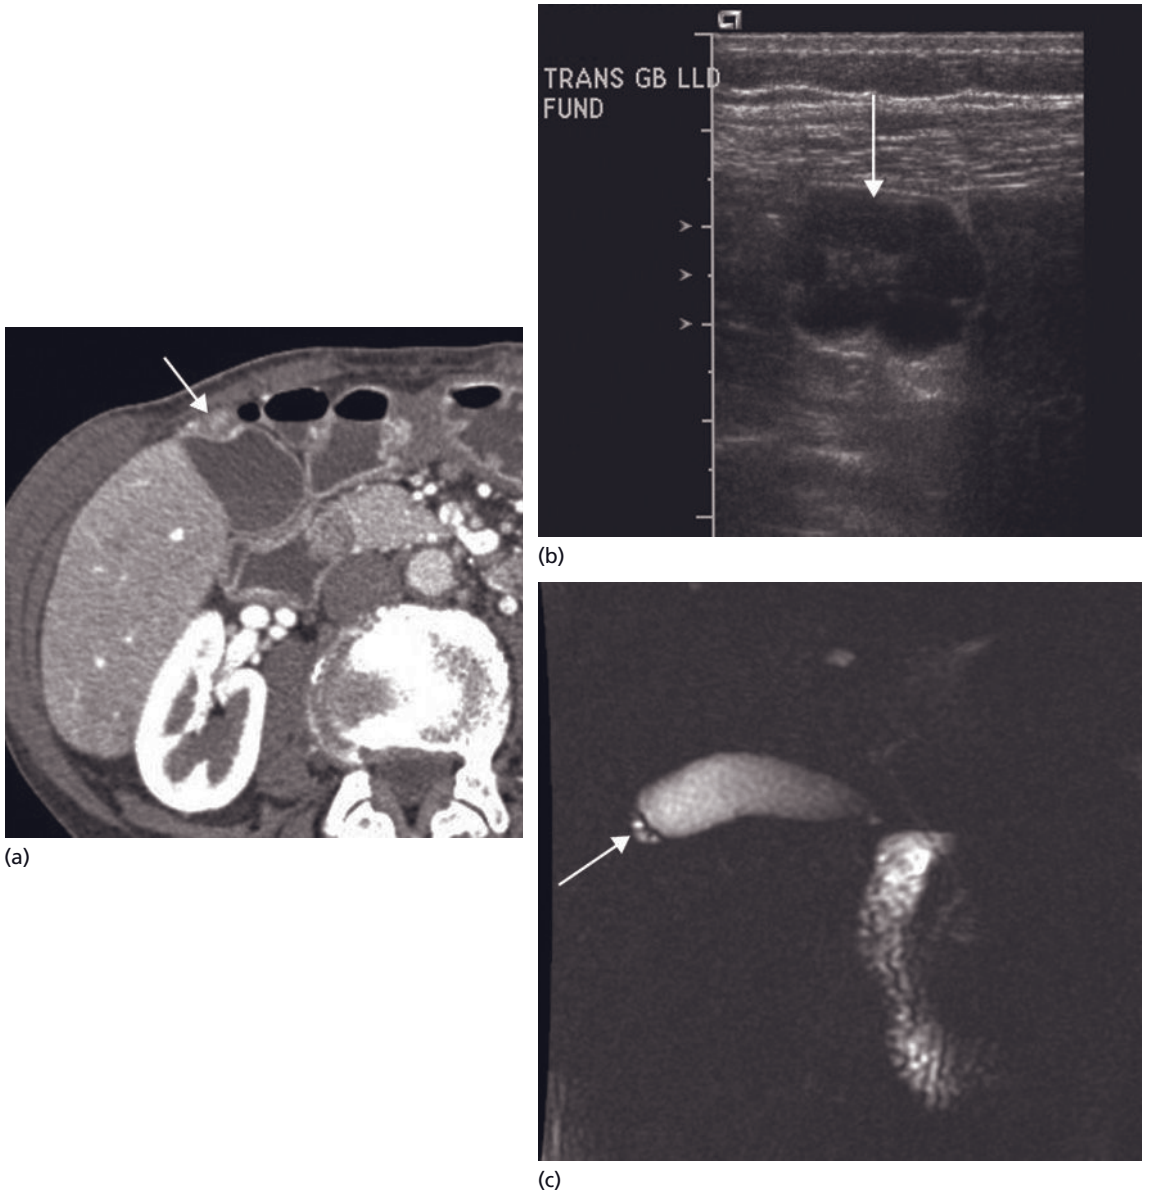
Focal adenomyomatosis. (a) Contrast-enhanced CT shows focal thickening of the gall-bladder fundus (arrow). (b) Corresponding ultrasound and (c) MRCP images demonstrate that the apparent focal thickening on CT is related to a cluster of cystic changes (arrows); incidental focal adenomyomatosis.
